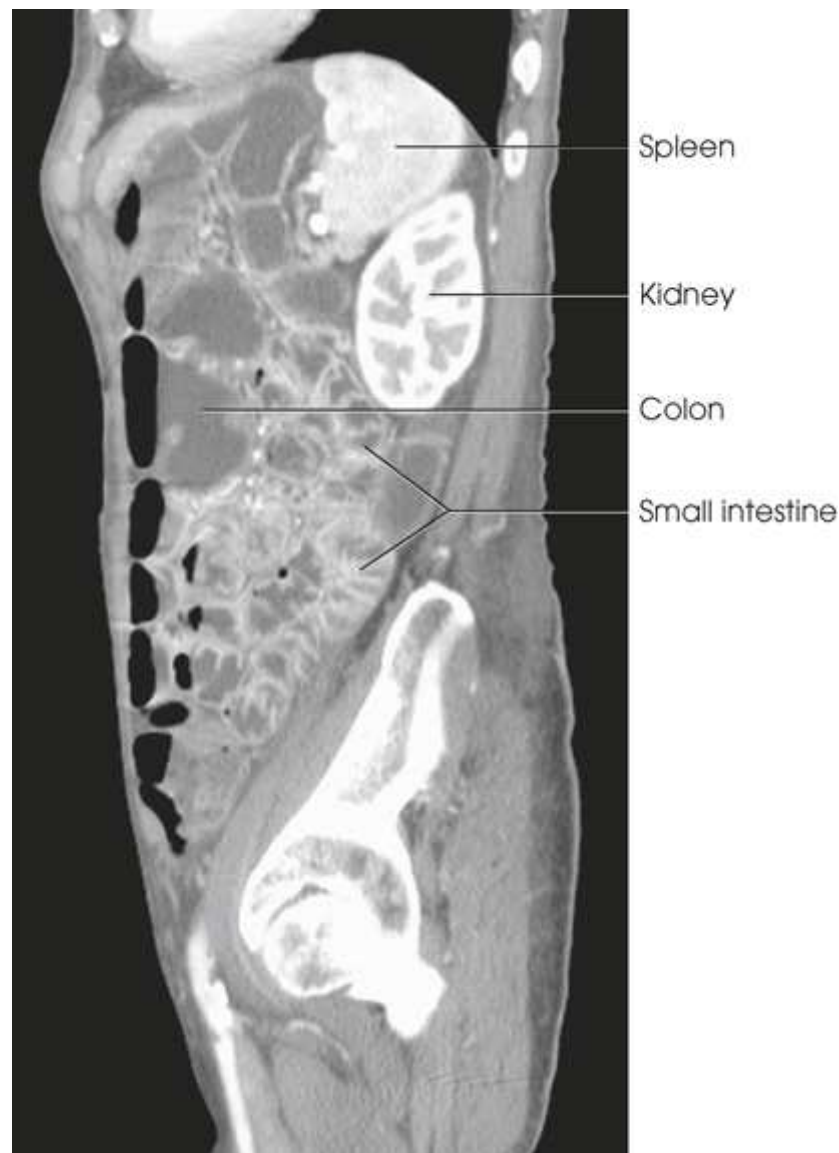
Sagittal reconstruction of CT enteroclysis from Fig. 15.93.
